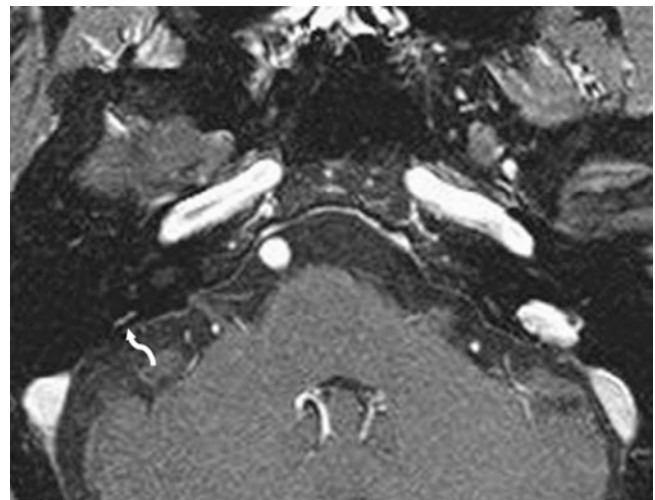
A 53-year-old with facial pain; an otherwise negative 1.5 T MRI axial postcontrast FS SET1WI showed mild right VA enhancement (*curved arrows*)
